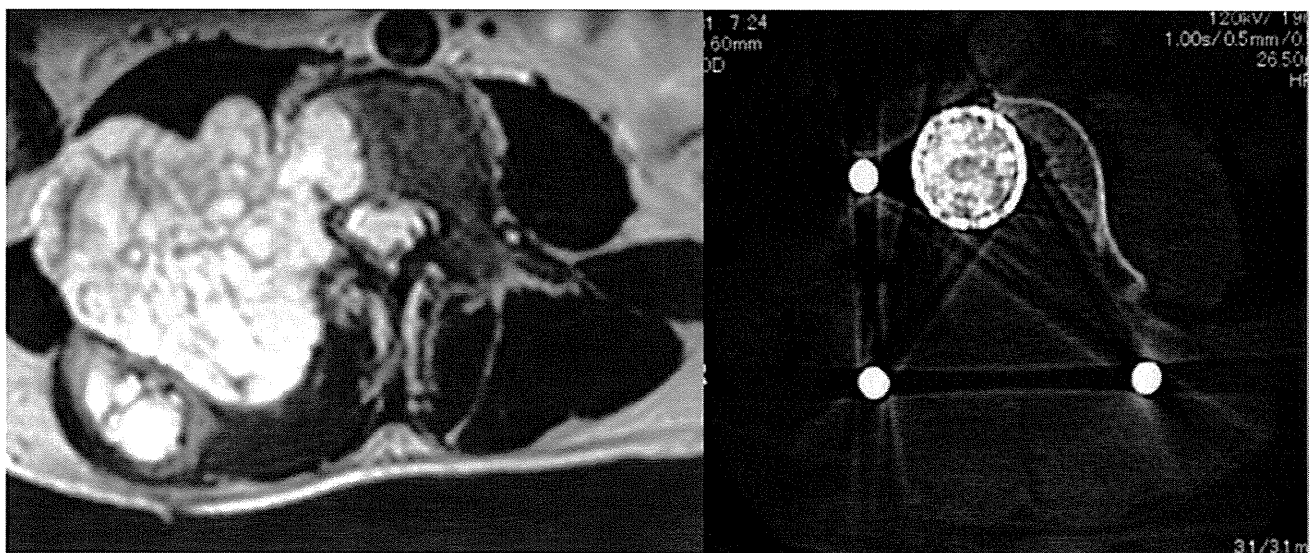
Case 2. Comparison of preoperative MR axial image (left) and postoperative (right) CT axial image. The images demonstrate the precise *en bloc* excision of a large tumor by spinal osteotomy and reconstruction using a titanium mesh cage with an autogenous bone graft.
